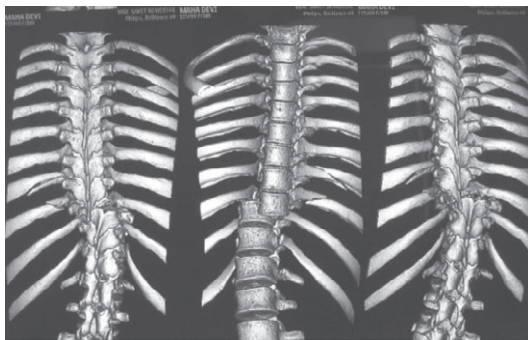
3D CT showing complete dorsolumbar disjunction
